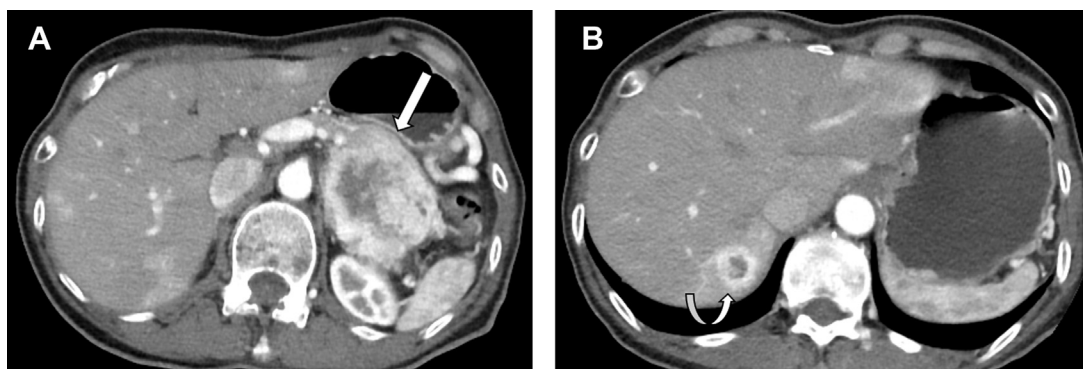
CT images in the arterial phase demonstrate a large heterogeneous enhancing mass (*arrow*) arising from the pancreatic tail (A) with a similar appearing metastatic lesion (*curved arrow*) in the liver (B). Subsequent biopsy confirmed nonfunctional metastatic pancreatic NETs.
